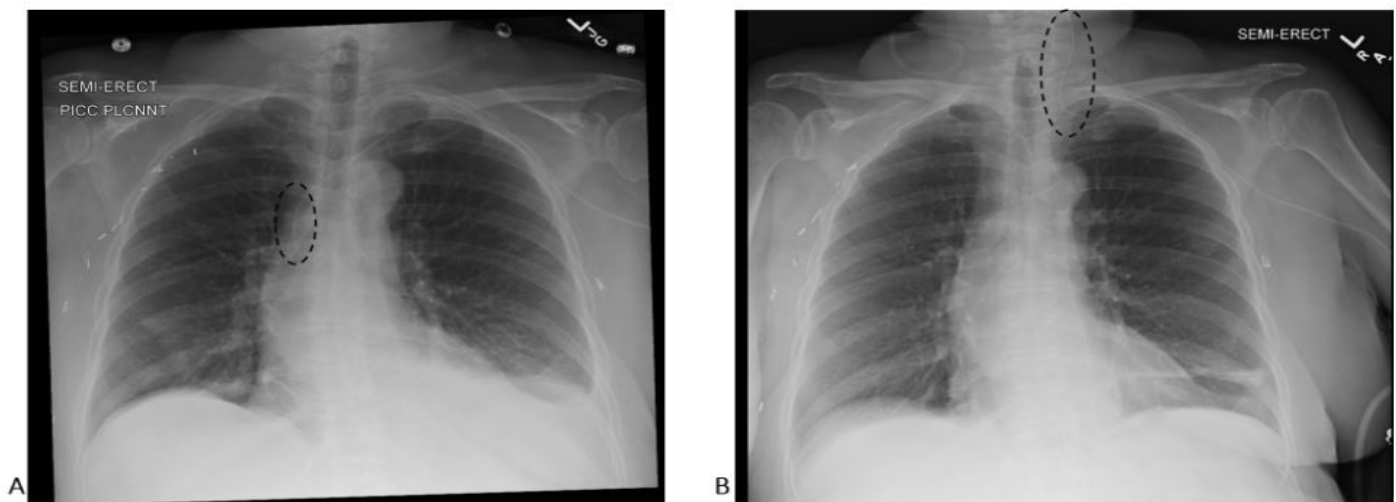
Portable chest radiographs demonstrating (A) initial placement of the left sided peripherally inserted central catheter in the middle superior vena cava; and (B) migration of the line to the left internal jugular vein (circles).
